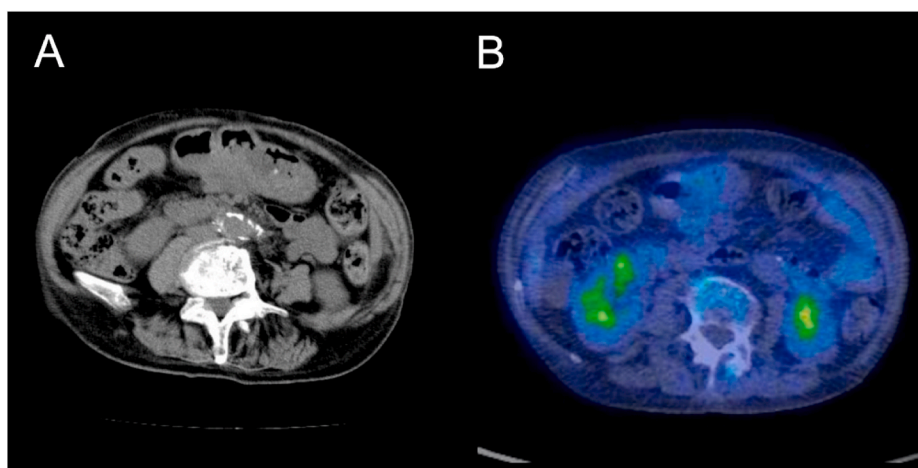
Abdominal computed tomography (CT) (A) and positron emission tomography-CT (B) after two cycles of S-1 treatment.
